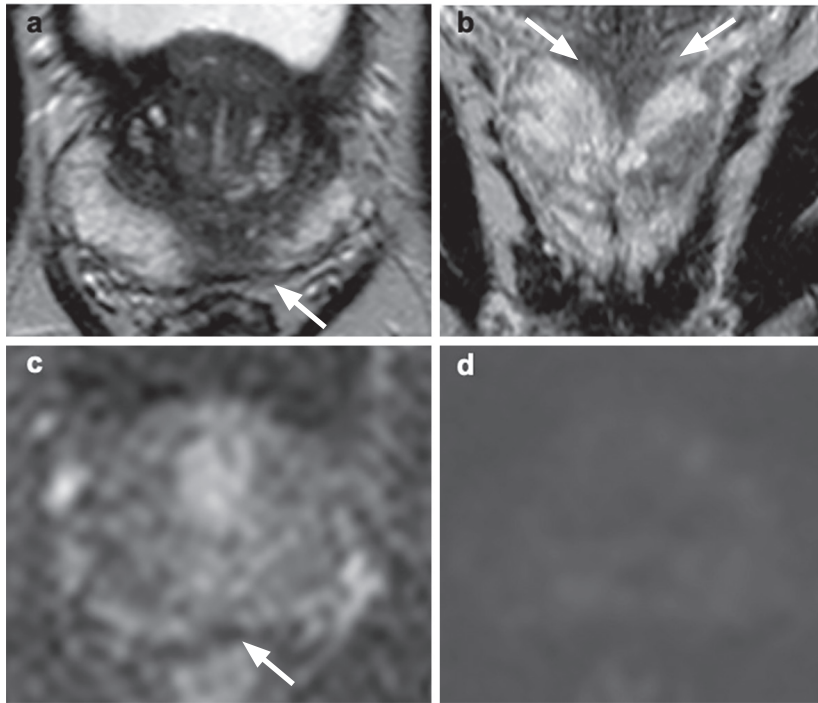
Prostate MRI Reversed Teardrop sign. (a-b) Axial and coronal T2WI with evidence of a median low signal intensity area at the middle third of the posterior zone (arrow). This posterior nodular-shaped area shows late contrast enhancement on perfusion sequences (c) and no hyperintensity on DWI (d). This sign represents the central zone compressed between the transition and peripheral zone. The use of the coronal plane is very important to demonstrate the continuity and symmetry of this area with the rest of the central portion. T2WI, T2-weighted image; DWI, Diffusion-Weighted Image.
